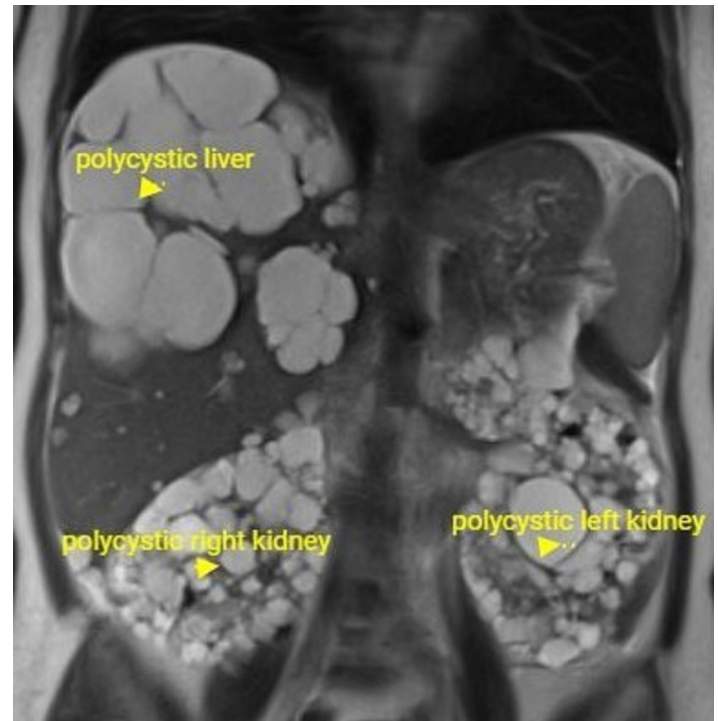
MRI image of ADPKD patient with PLD
